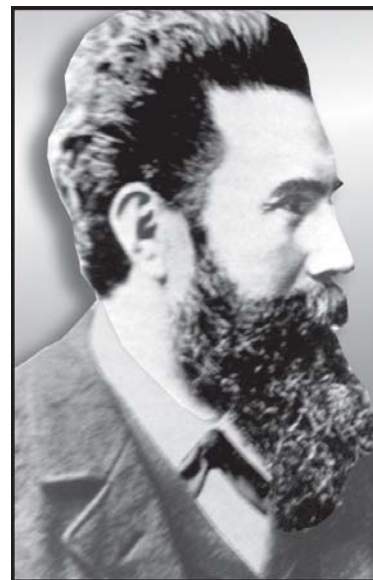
Wilhelm Conrad Roentgen (1845-1925) – The discoverer of X-rays
